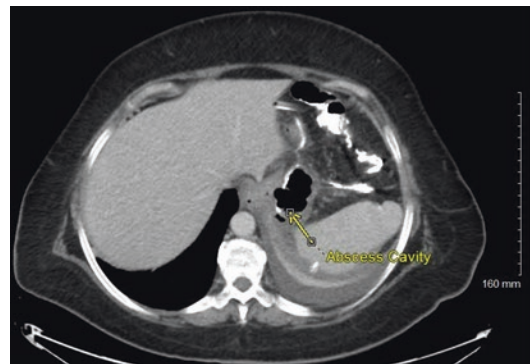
CT scan of same patient from Fig. 7.2 showing the abscess cavity between the gastric sleeve staple line and the spleen
